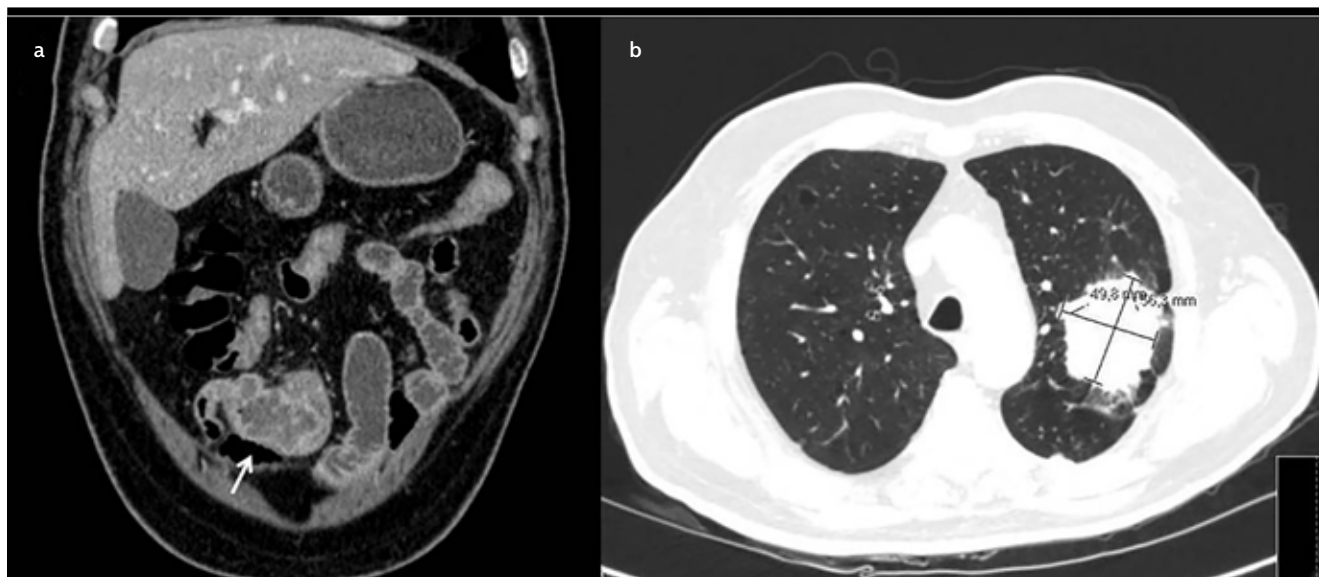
a, b. Abdominal computerized tomography (CT) scan revealed focal thickening of the ileal segment (a); additional thoracic CT revealed a left upper lobe mass (50×55 mm) (b)
